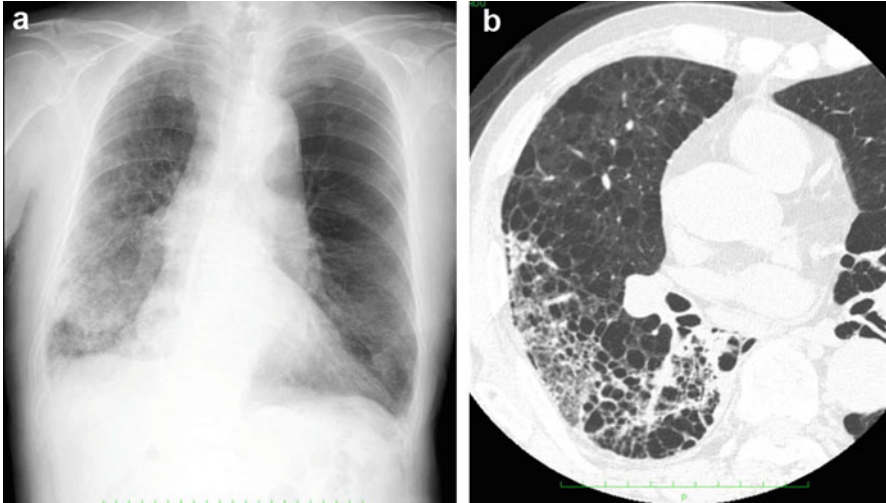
Pneumonia and emphysema (Swiss cheese appearance). (a) Chest x-ray shows overinflation of both lungs. Abnormal opacity is noted in the right middle to lower lung fields. (b) High-resolution computed tomography (HRCT) shows a multicystic shadow and ground-glass opacity/consolidation in the right lower lobe. Emphysema is evident in the lung fields without ground-glass opacity/consolidation
